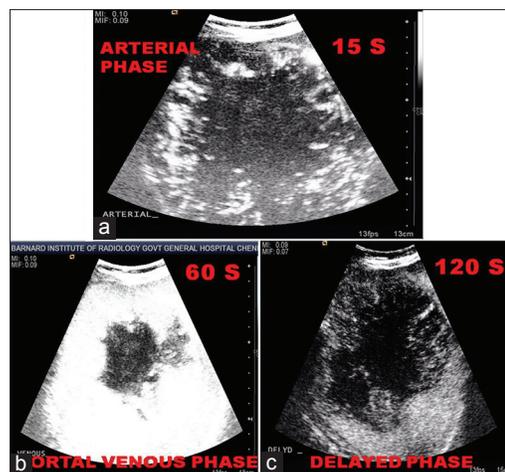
(a-c) Contrast-enhanced real-time ultrasonography - Arterial phase: Peripheral nodular or globular enhancement, no central enhancement, rim enhancement; portal vein phase: Partial/complete centripetal filling; parenchymal phase: Persistent enhancement. Typical hemangioma
